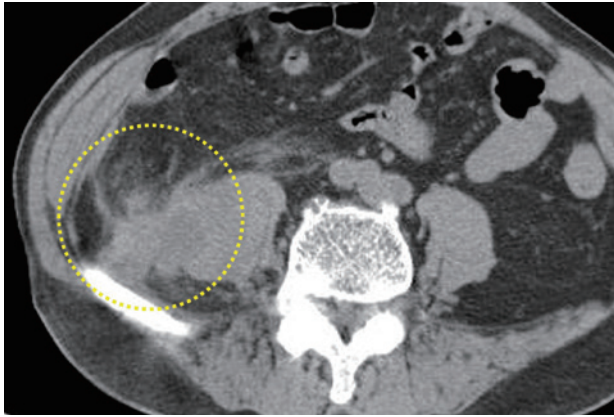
Abdominal CT images at the out-patient department showing a right iliopsoas space occupying lesion (yellow dotted circle)
